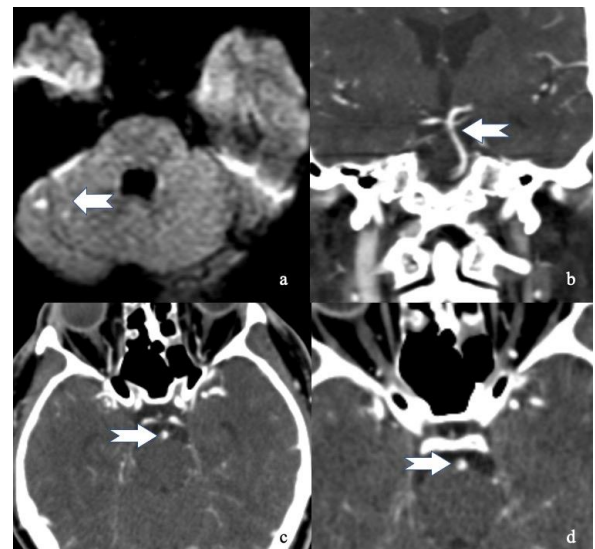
Diffusion-weighted imaging (DWI) at admission of Case 1. Arrow show the acute ischemic lesion at cerebellum, b. CTA coronal plane, c. CTA axial plane, d. CTA axial plane with magnification, arrows showing partial thrombus.
